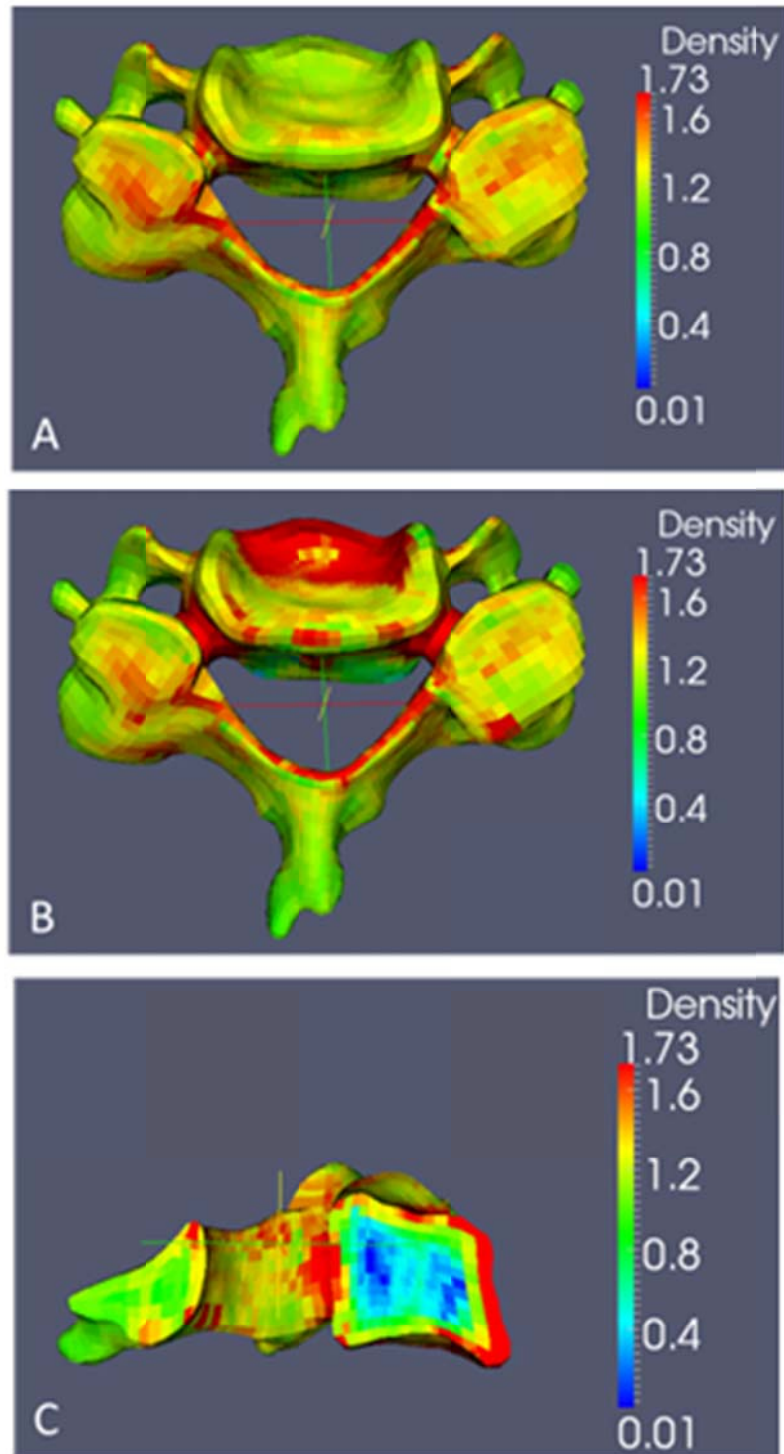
Density distribution in an intact C5 vertebrae (A) CT based material properties (B) Optimized material properties (Superior View) (C) Optimized material properties (Sagittal View).
